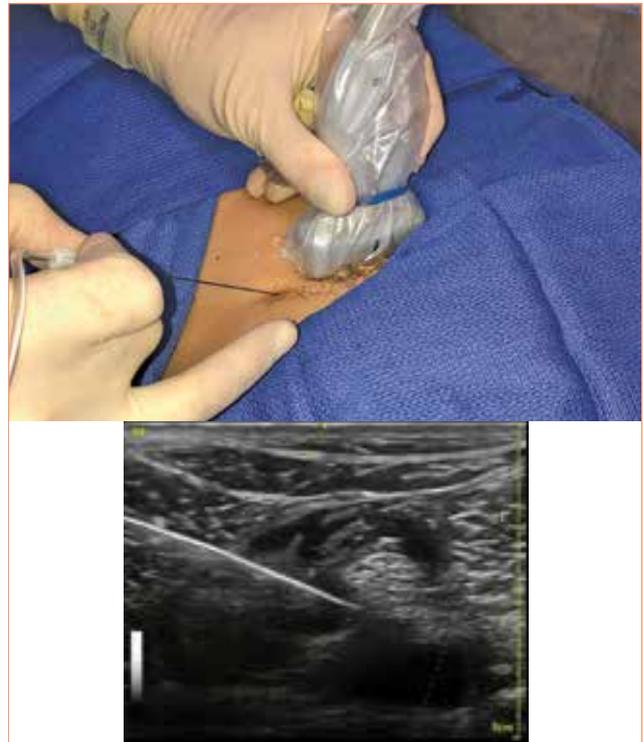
Ultrasound-Guided Femoral Nerve Block²⁴
